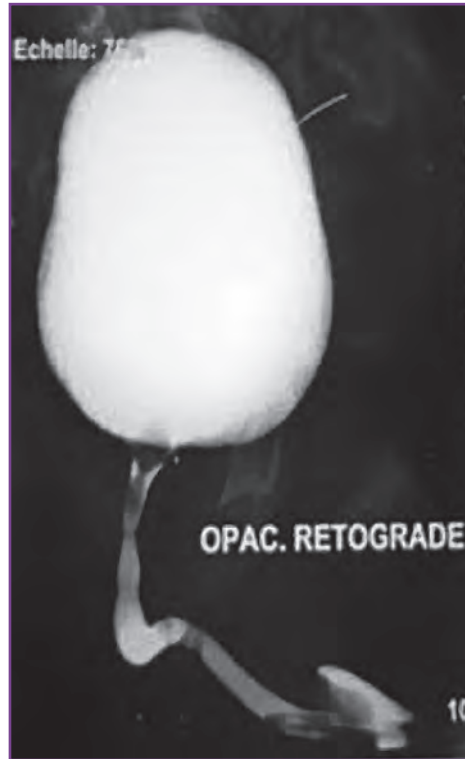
Voiding cystourethrogram in a 15-month-old boy shows the radiographic appearance of a benign posterior urethral polyp, just below the bladder neck, which is causing urinary retention.
